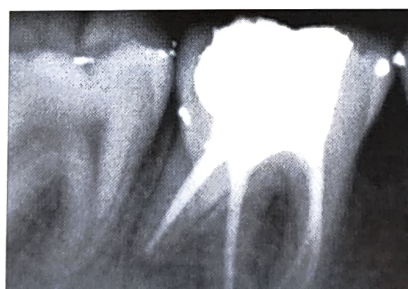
Post obturation X-ray
